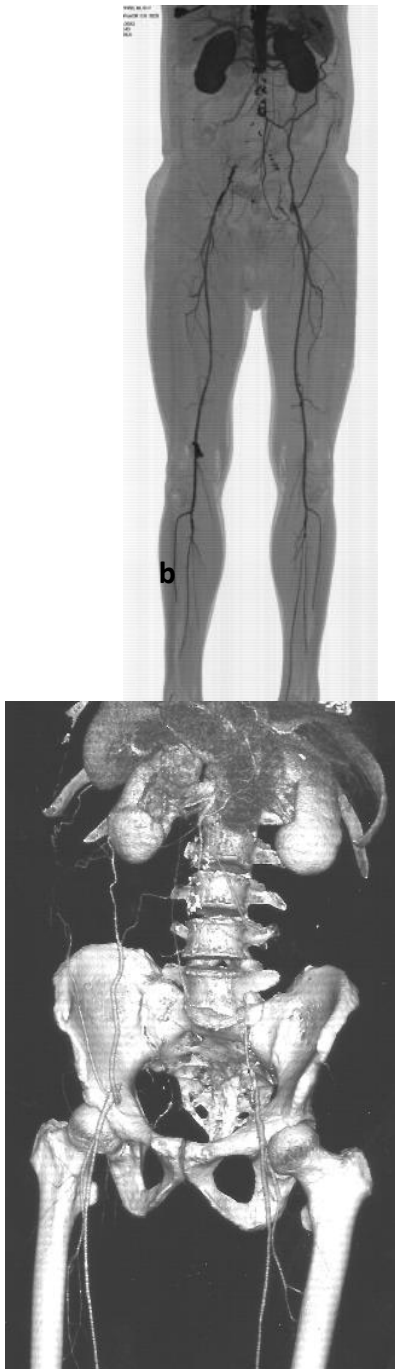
(a,b)- Digital angiography and angio-CT showing infrarenal aortic occlusion with refilling of the femoral and popliteal and distal calf arteries
